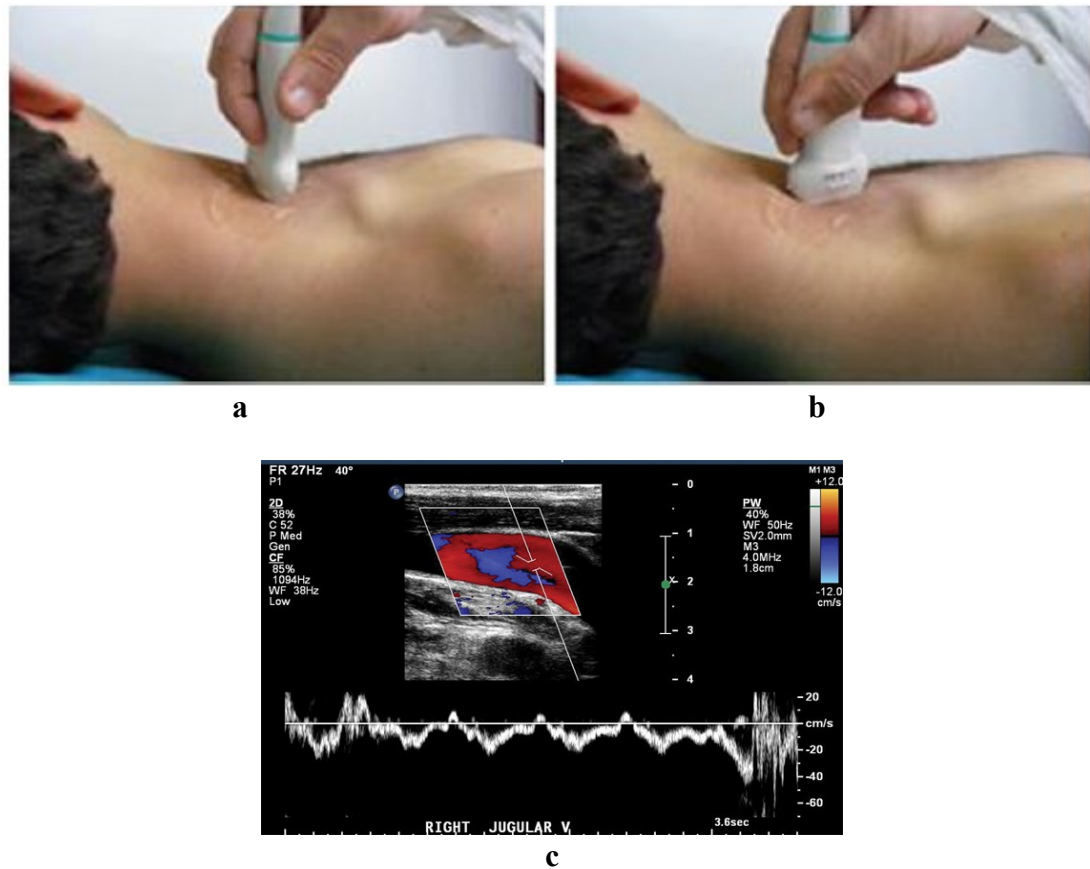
Detection of CVP using IJV ultrasound: (a) transverse scan, (b) lateral scan, (c) Normal phasic and normal directional venous flow in the right IJV. Reproduced from (Unluer and Kara 2013, and Yan and Seow 2009).
